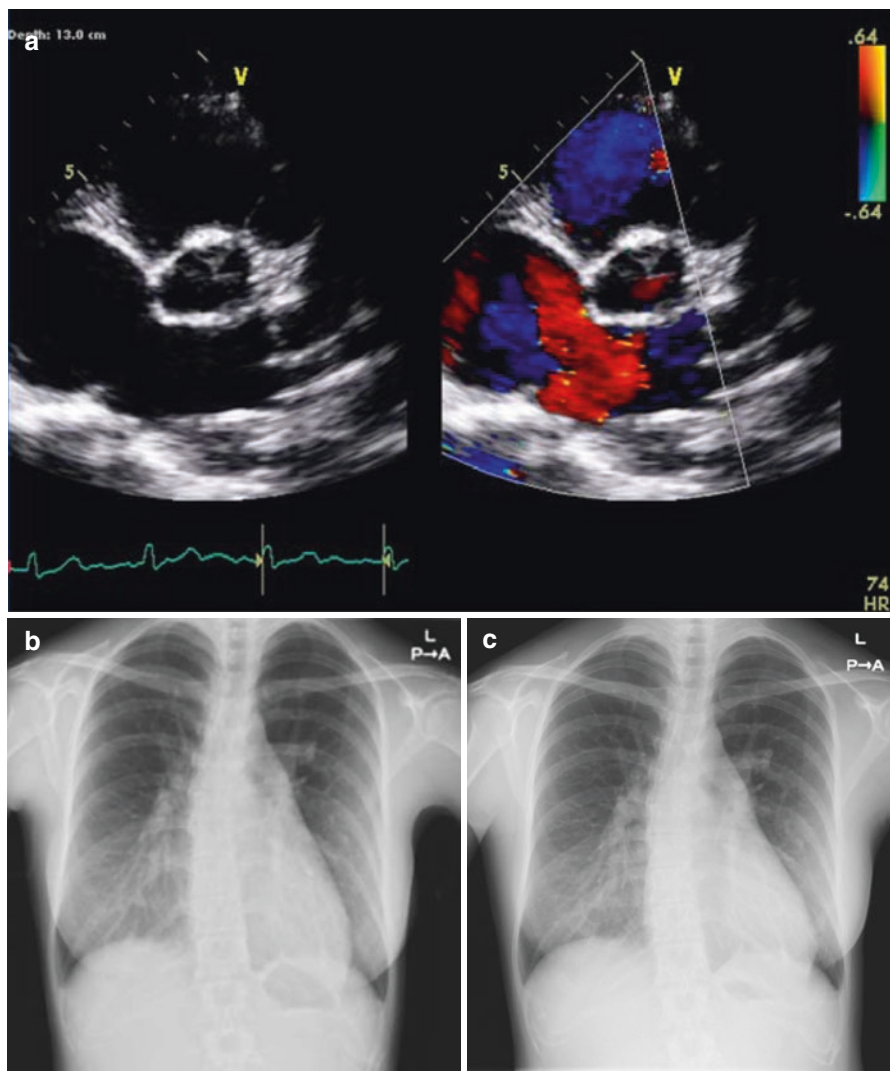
A clinical course of pregnancy complicated with significantly large atrial septal defect. She had rejected an operation for her large atrial septal defect (estimated $Qp/Qs > 3$ by echocardiography, a) and got pregnant. Her chest X-rays showed enlargement of cardiac silhouette due to pregnancy-induced volume extension (b, taken before pregnancy; c, taken in postpartum). She complained of mild dyspnea 2 days after delivery. She took diuretics for 3 days, and her symptom resolved
